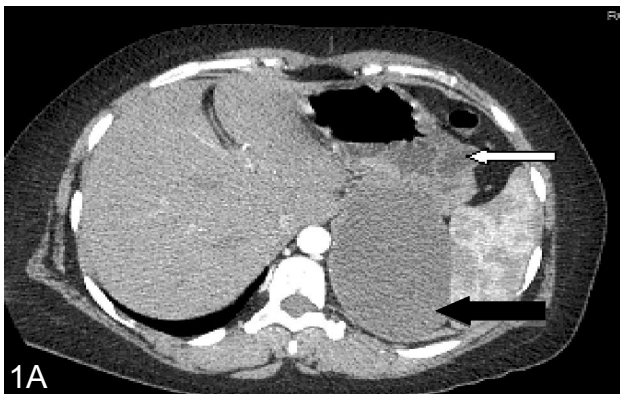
Axial CT scan post contrast showing larger hypodense cystic area with mild enhancement of walls (curved arrow) along greater curvature and posterior wall of stomach (black arrow). another small intramural cystic lesion is seen within the wall of greater curvature and anterior wall of stomach (white arrow).
